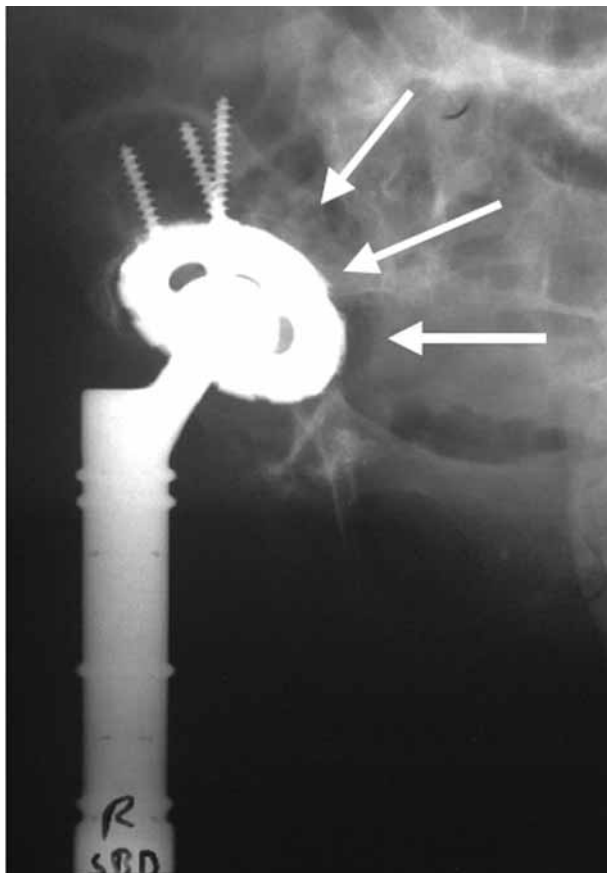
Plain radiograph of the right hip revealing acetabular protrusion (→) due to loosening of the Wagner cup.
